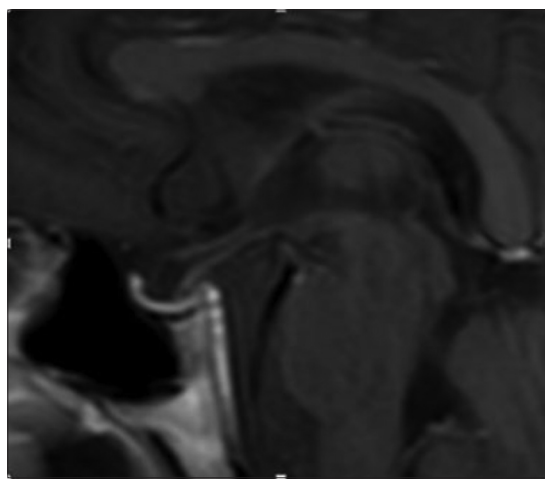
Sagittal postcontrast T1 magnetic resonance imaging showing thin enhancing tissue along the floor of the pituitary fossa with cerebrospinal fluid (CSF) occupying the rest of the fossa suggesting a partially empty sella
